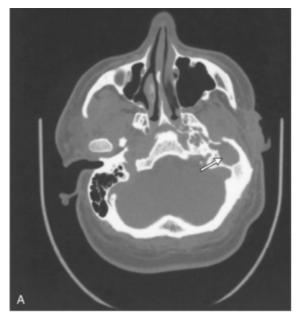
A, Computed tomography scan demonstrating a left-sided cholesteatoma (*arrow*) in a patient with canal atresia who had a brain abscess (*arrow*) as seen on magnetic resonance imaging (B).
